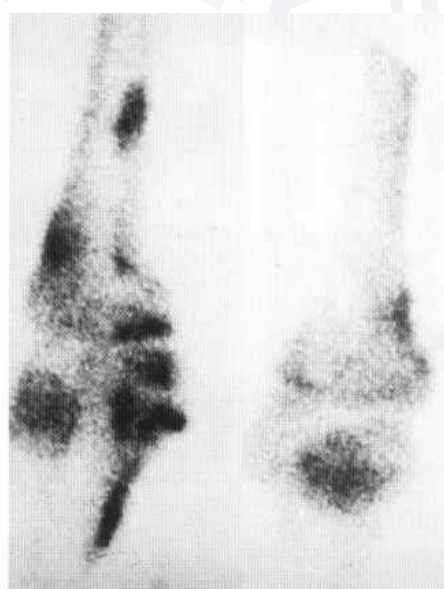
Melorheostosis. (A) The plain film shows eccentric and irregular sclerosis along the medial aspect of the distal femur, crossing the joint into the adjacent tibia. There is new bone on the outer aspect of the cortex and also in the soft tissues. (B) On the radioisotope bone scan increase in uptake is demonstrated in the areas of bone sclerosis. (C) The coronal T₁-weighted MR sequence shows sclerotic bone, as expected, as areas of low signal lying within the marrow, on the periosteum and in the soft tissues.
